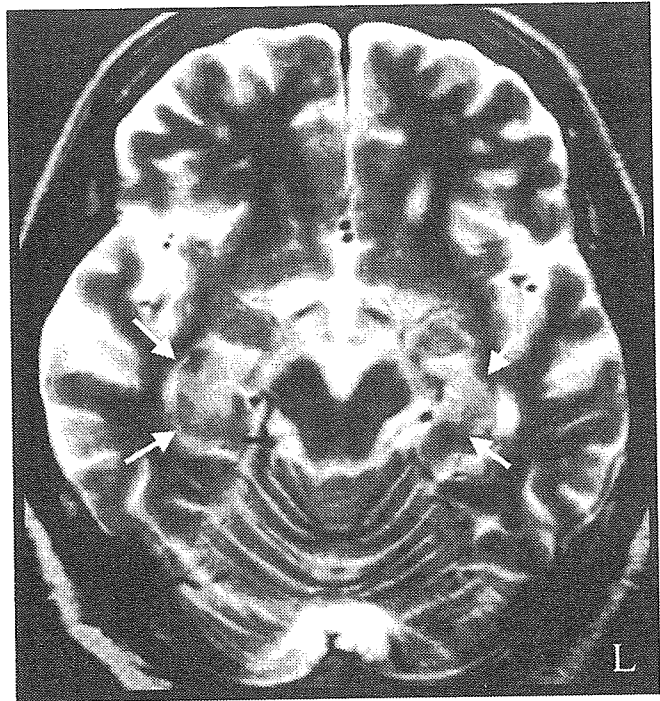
Approximately 20 days after onset, T2-weighted axial MRI (1.5 T superconducting magnet system, SE 4,000/88) revealed bilateral hippocampal lesions (arrows).
